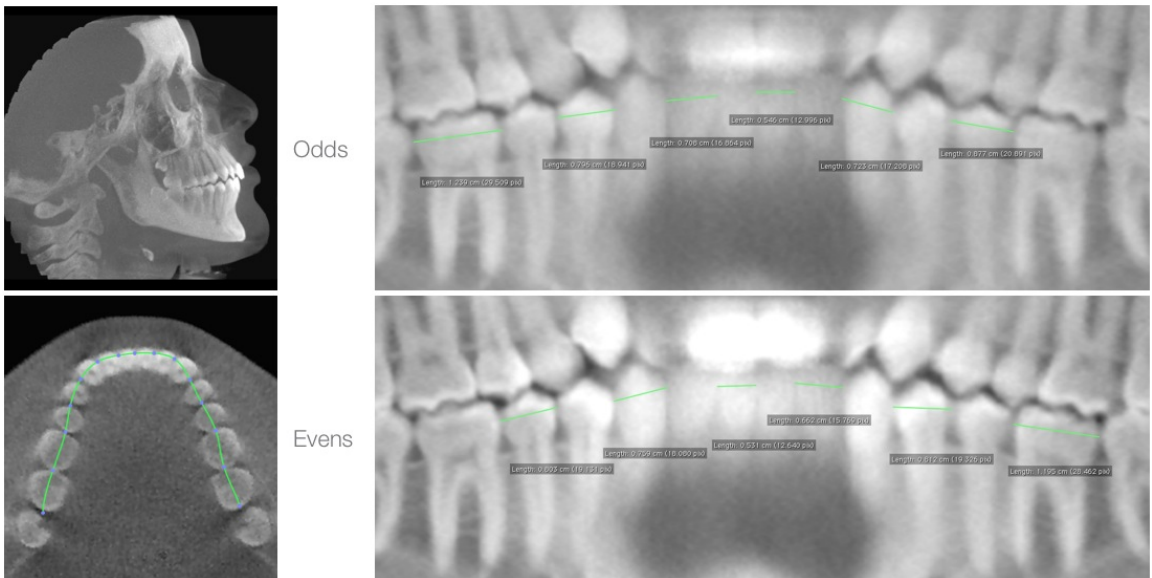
Method 2: CBCT Detailed Pano - OsiriX (Mandible).
